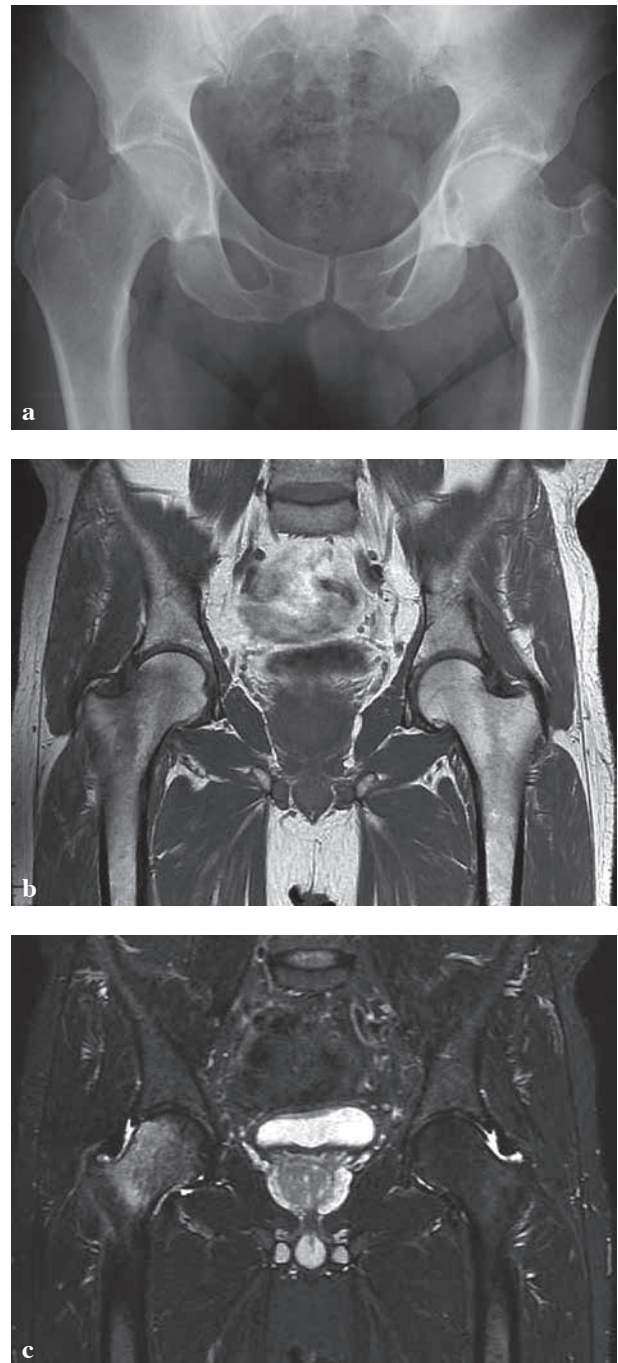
(a) Osteopenia in the right femoral head and neck on hip X-Ray examination. The left hip is normal. (b) The coronal T1-weighted image of the hip joint shows a low signal intensity lesion in the right femoral head (arrow). (c) high signal intensity lesion on fat suppressed coronal T2 weighted image (arrow).
